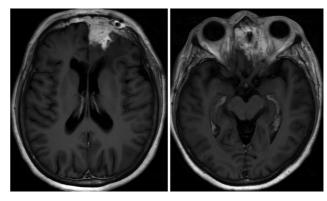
Axial brain magnetic resonance imaging demonstrating edema with T2 enhancement in the left frontal lobe, and enhancement extension to the paranasal sinuses and through the cribriform plate.
